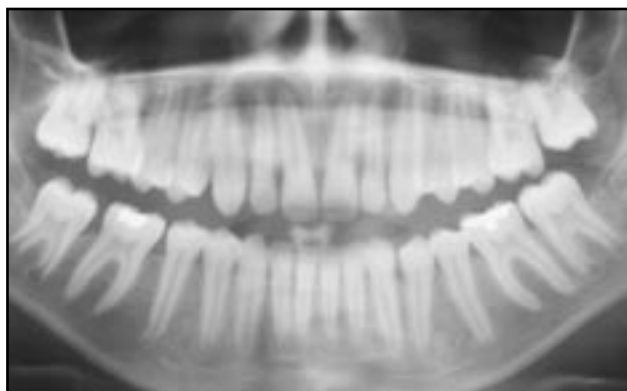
Case 1: Radiographic view 13 months postoperatively showing normal features and eruption of mandibular second premolar.
